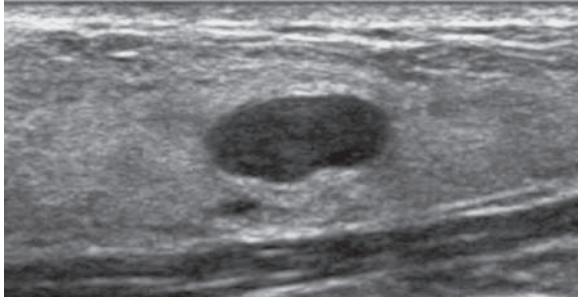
Typical sonographic features of a benign solid mass. This mass is oriented “parallel” to the skin (“wider-than-tall”), oval with circumscribed margins and <3 gentle lobulations. Findings are typical for a fibroadenoma
